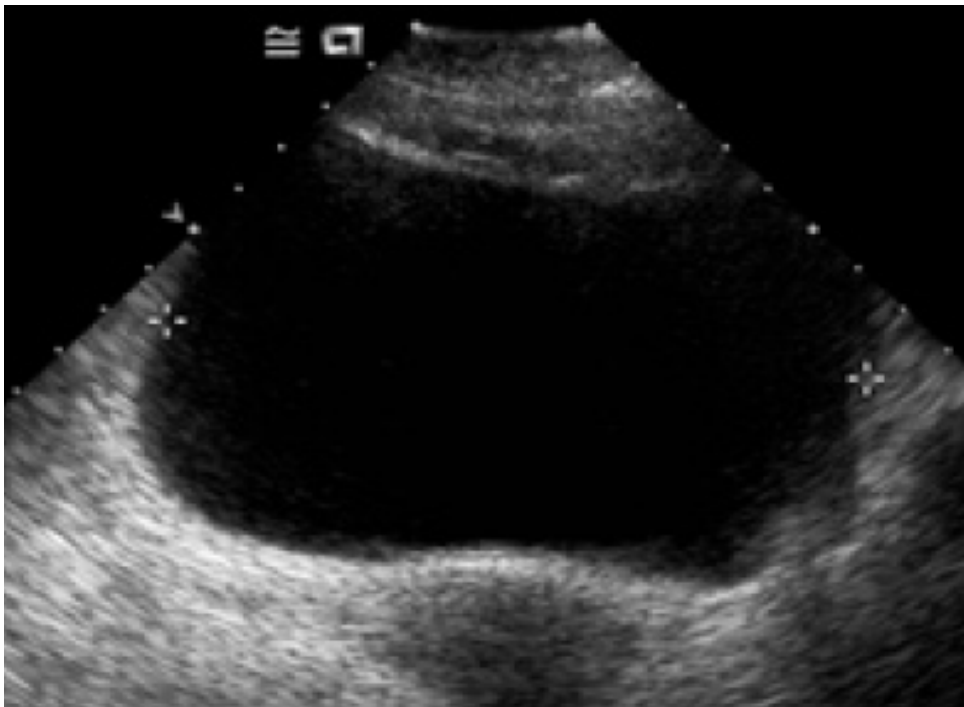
A postvoid residual volume obtained by noninvasive bladder ultrasonography reveals 1000 mL
